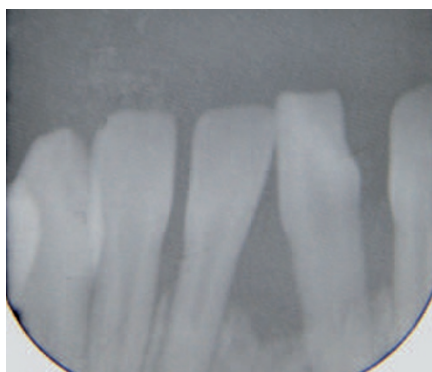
Radiograph showing horizontal bone loss
